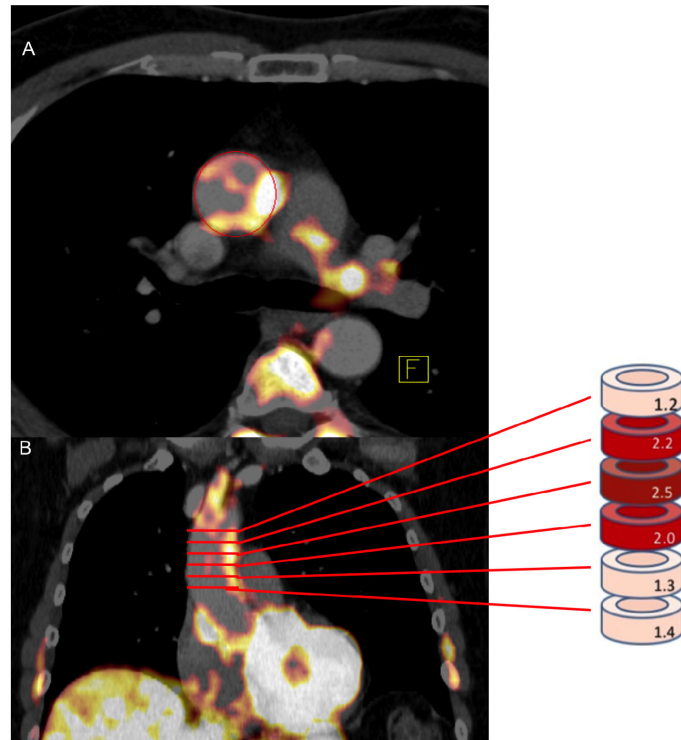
Image of PET analysis. SUV is measured in wall of the Ascending aorta in the axial plane (A) starting 1 cm above the origin of coronary vessels and continuing to the bottom of the aortic arch in 5 mm increments (B). Arterial FDG uptake was recorded as a mean of maximum standardized uptake values (SUV_{max}) of all the slices.
